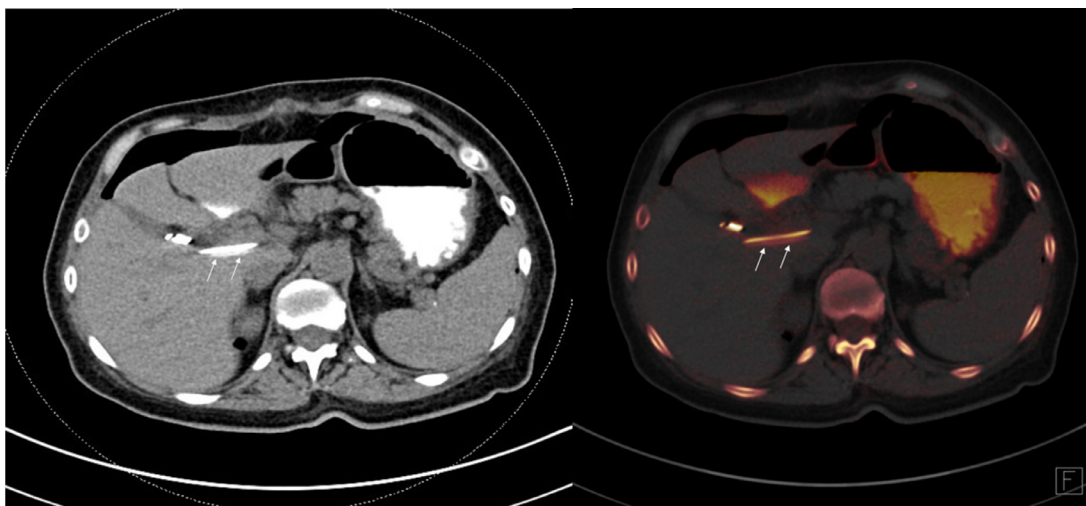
(A): (left) Axial slice of a dual energy CT abdomen/pelvis without IV contrast but with oral iodinated contrast demonstrating no clear presence of anastomotic leak. The white arrows point to a longitudinal slice of the tubing, again demonstrating that the hyper-attenuation within the tube looks similar to artifact from the Barium strip. (B): (right) Iodine overlay reconstruction of Fig. 3A demonstrating attenuation of the surgical drain tubing contents clearly eccentric from the barium strip (white arrows).
